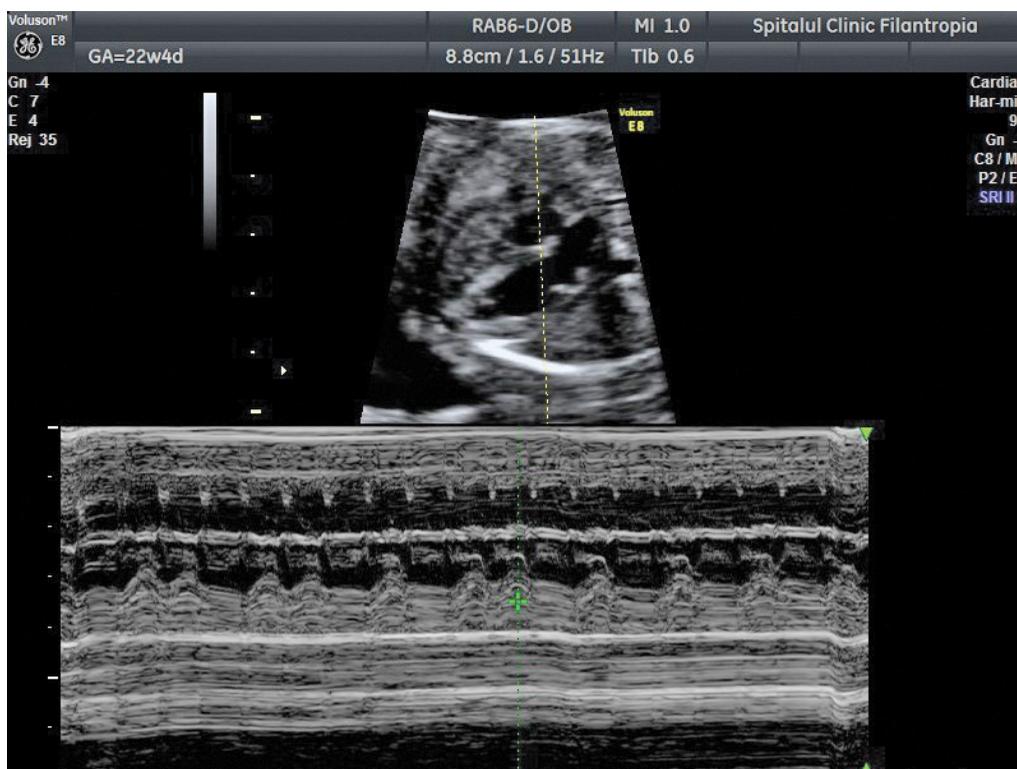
Echocardiography of the fetal heart at 22 weeks of pregnancy in a mother with anti-Ro antibodies. M-mode. The beam record sequential contraction of the atrial and ventricular walls and this is displayed in the image. There is grade 2 intermittent fetal atrioventricular (AV) block
